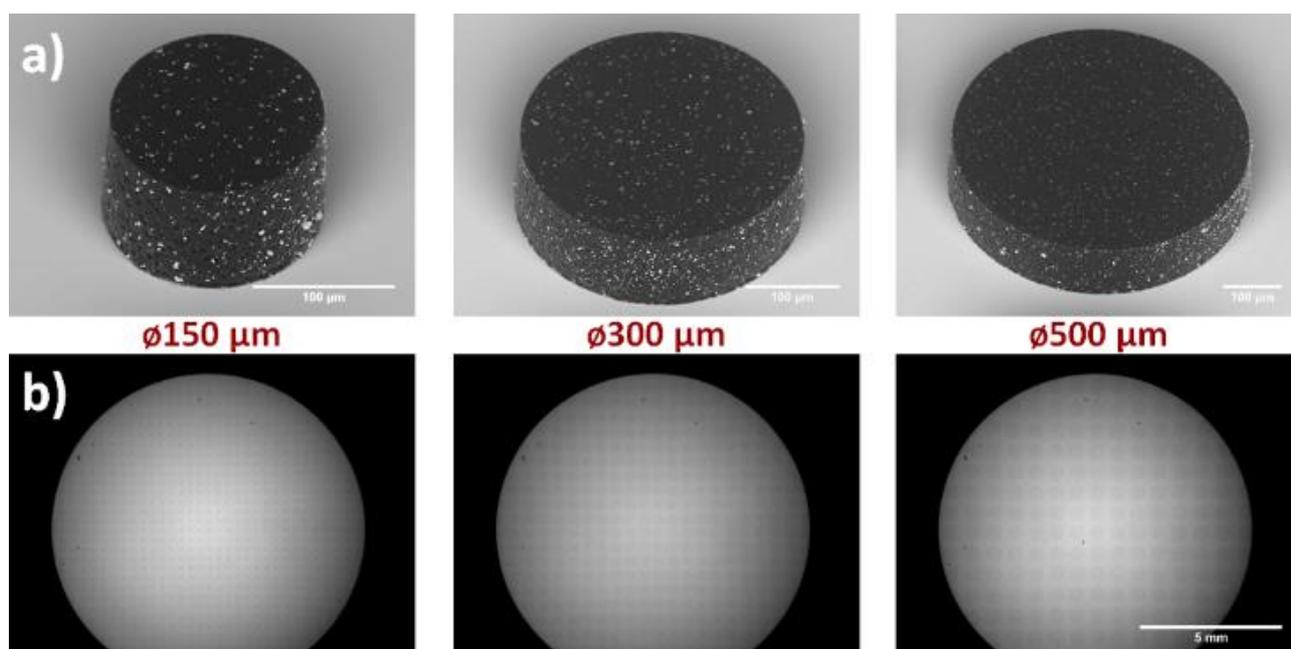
a) SEM images of fabricated microparticles with incorporated BaSO₄ (diameters of 150 μm, 300 μm and 500 μm, respectively). b) X-ray images of chips with the three different types of microparticles.
